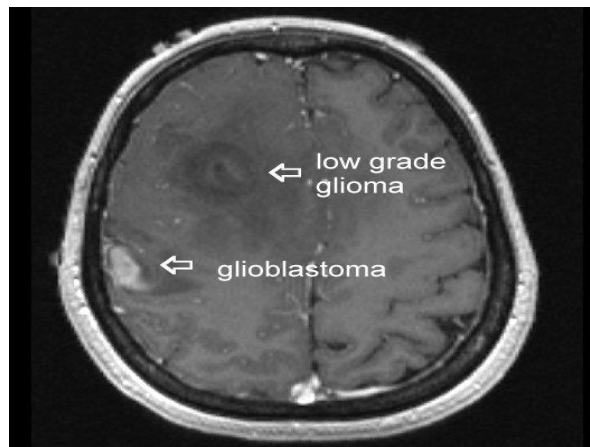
Figuer (2-14): MRI brain axial T1 with contrast
